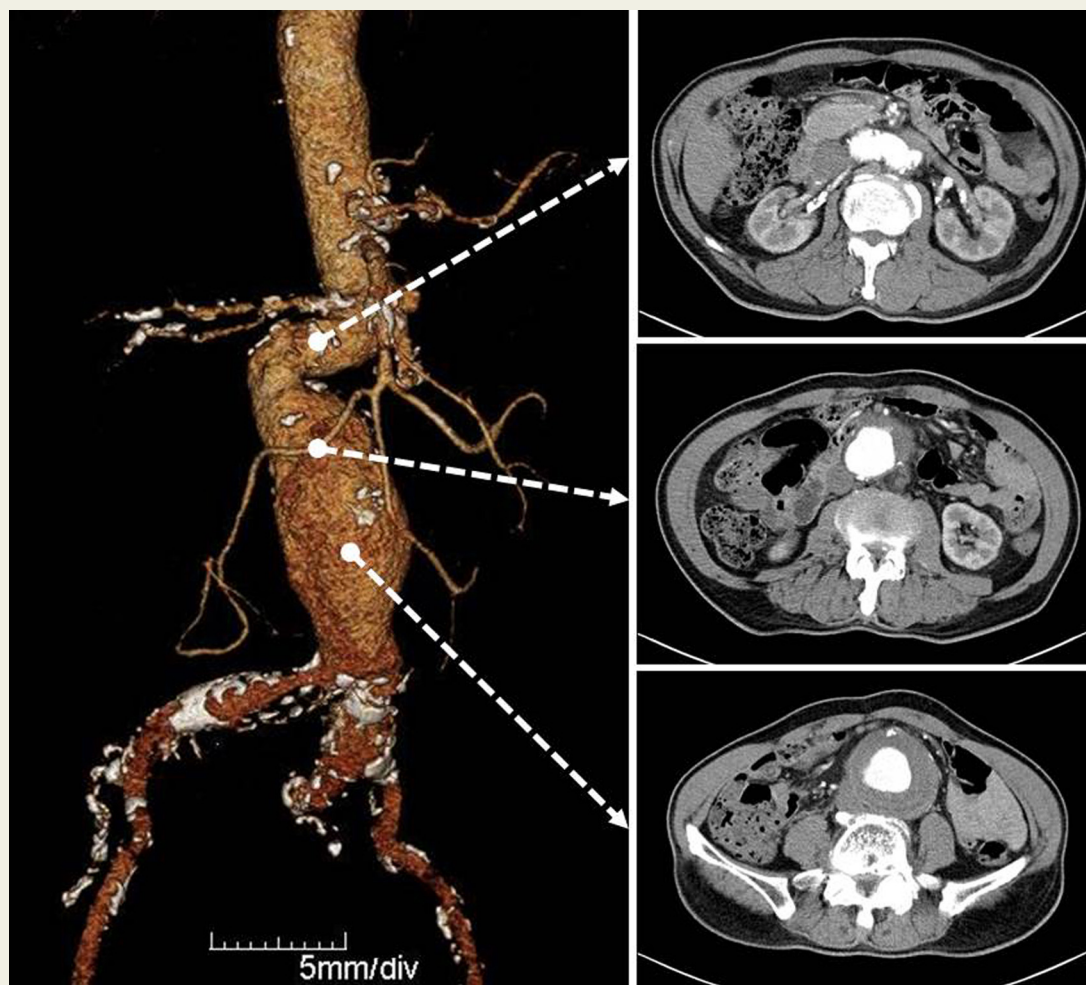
Preoperative atrial phase 2-dimensional (right panel, axial section of abdomen) and 3-dimensional (left panel) reconstruction computed tomography image of abdominal aortic aneurysm with a severely angulated aortic neck (86.5° , between the infrarenal segment and aneurysmal sac).
